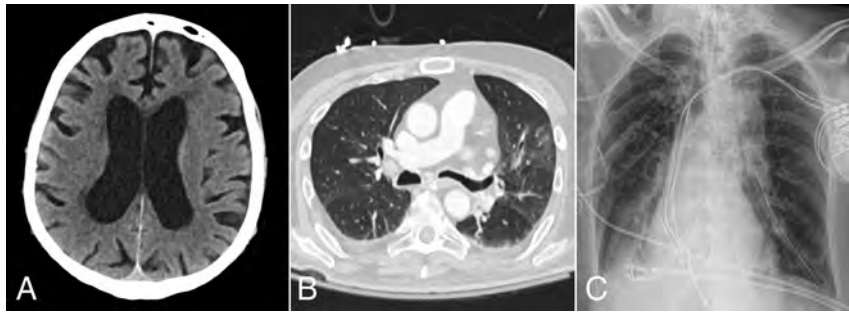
A 67-year-old woman presented with hypoxemic respiratory failure. Axial non-contrast-enhanced head CT image (A) shows no acute findings. B, Chest CT image of the patient demonstrates bilateral peripherally distributed ground-glass opacities involving 4 of the 5 lobes with a CCS score of 8. D, Portable chest radiograph demonstrates bibasilar patchy opacities with a PXS score of 4.4.
